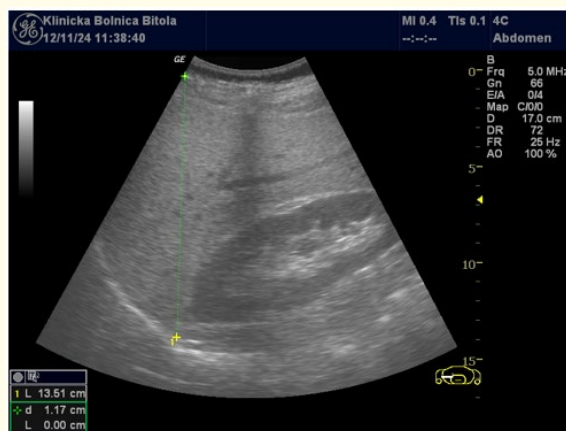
B-mode Ultrasonography demonstrating non-alcoholic fatty liver disease (NAFLD) in male patients with chronic obstructive pulmonary disease (COPD).
